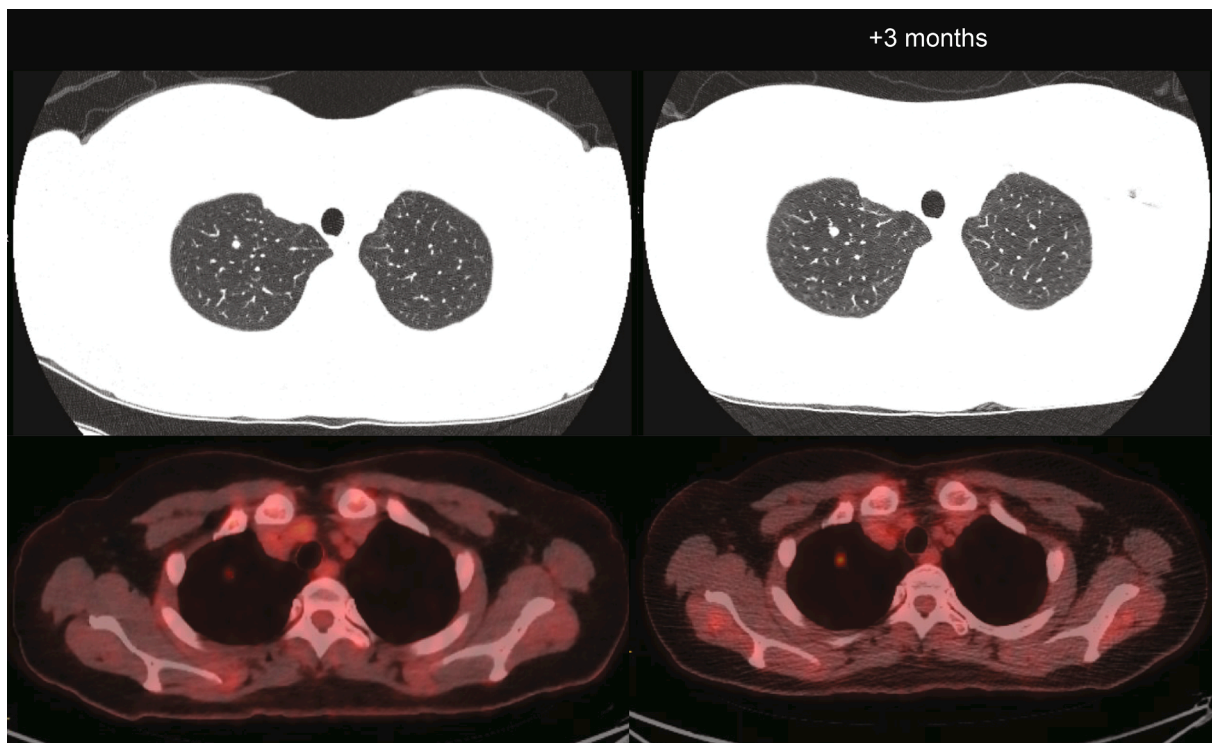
PET and CT chest imaging of a solitary lung nodule over 3 months; its size remained relatively unchanged of about 4 mm with a mild SUV max increase from 1.5 to 3.2.
